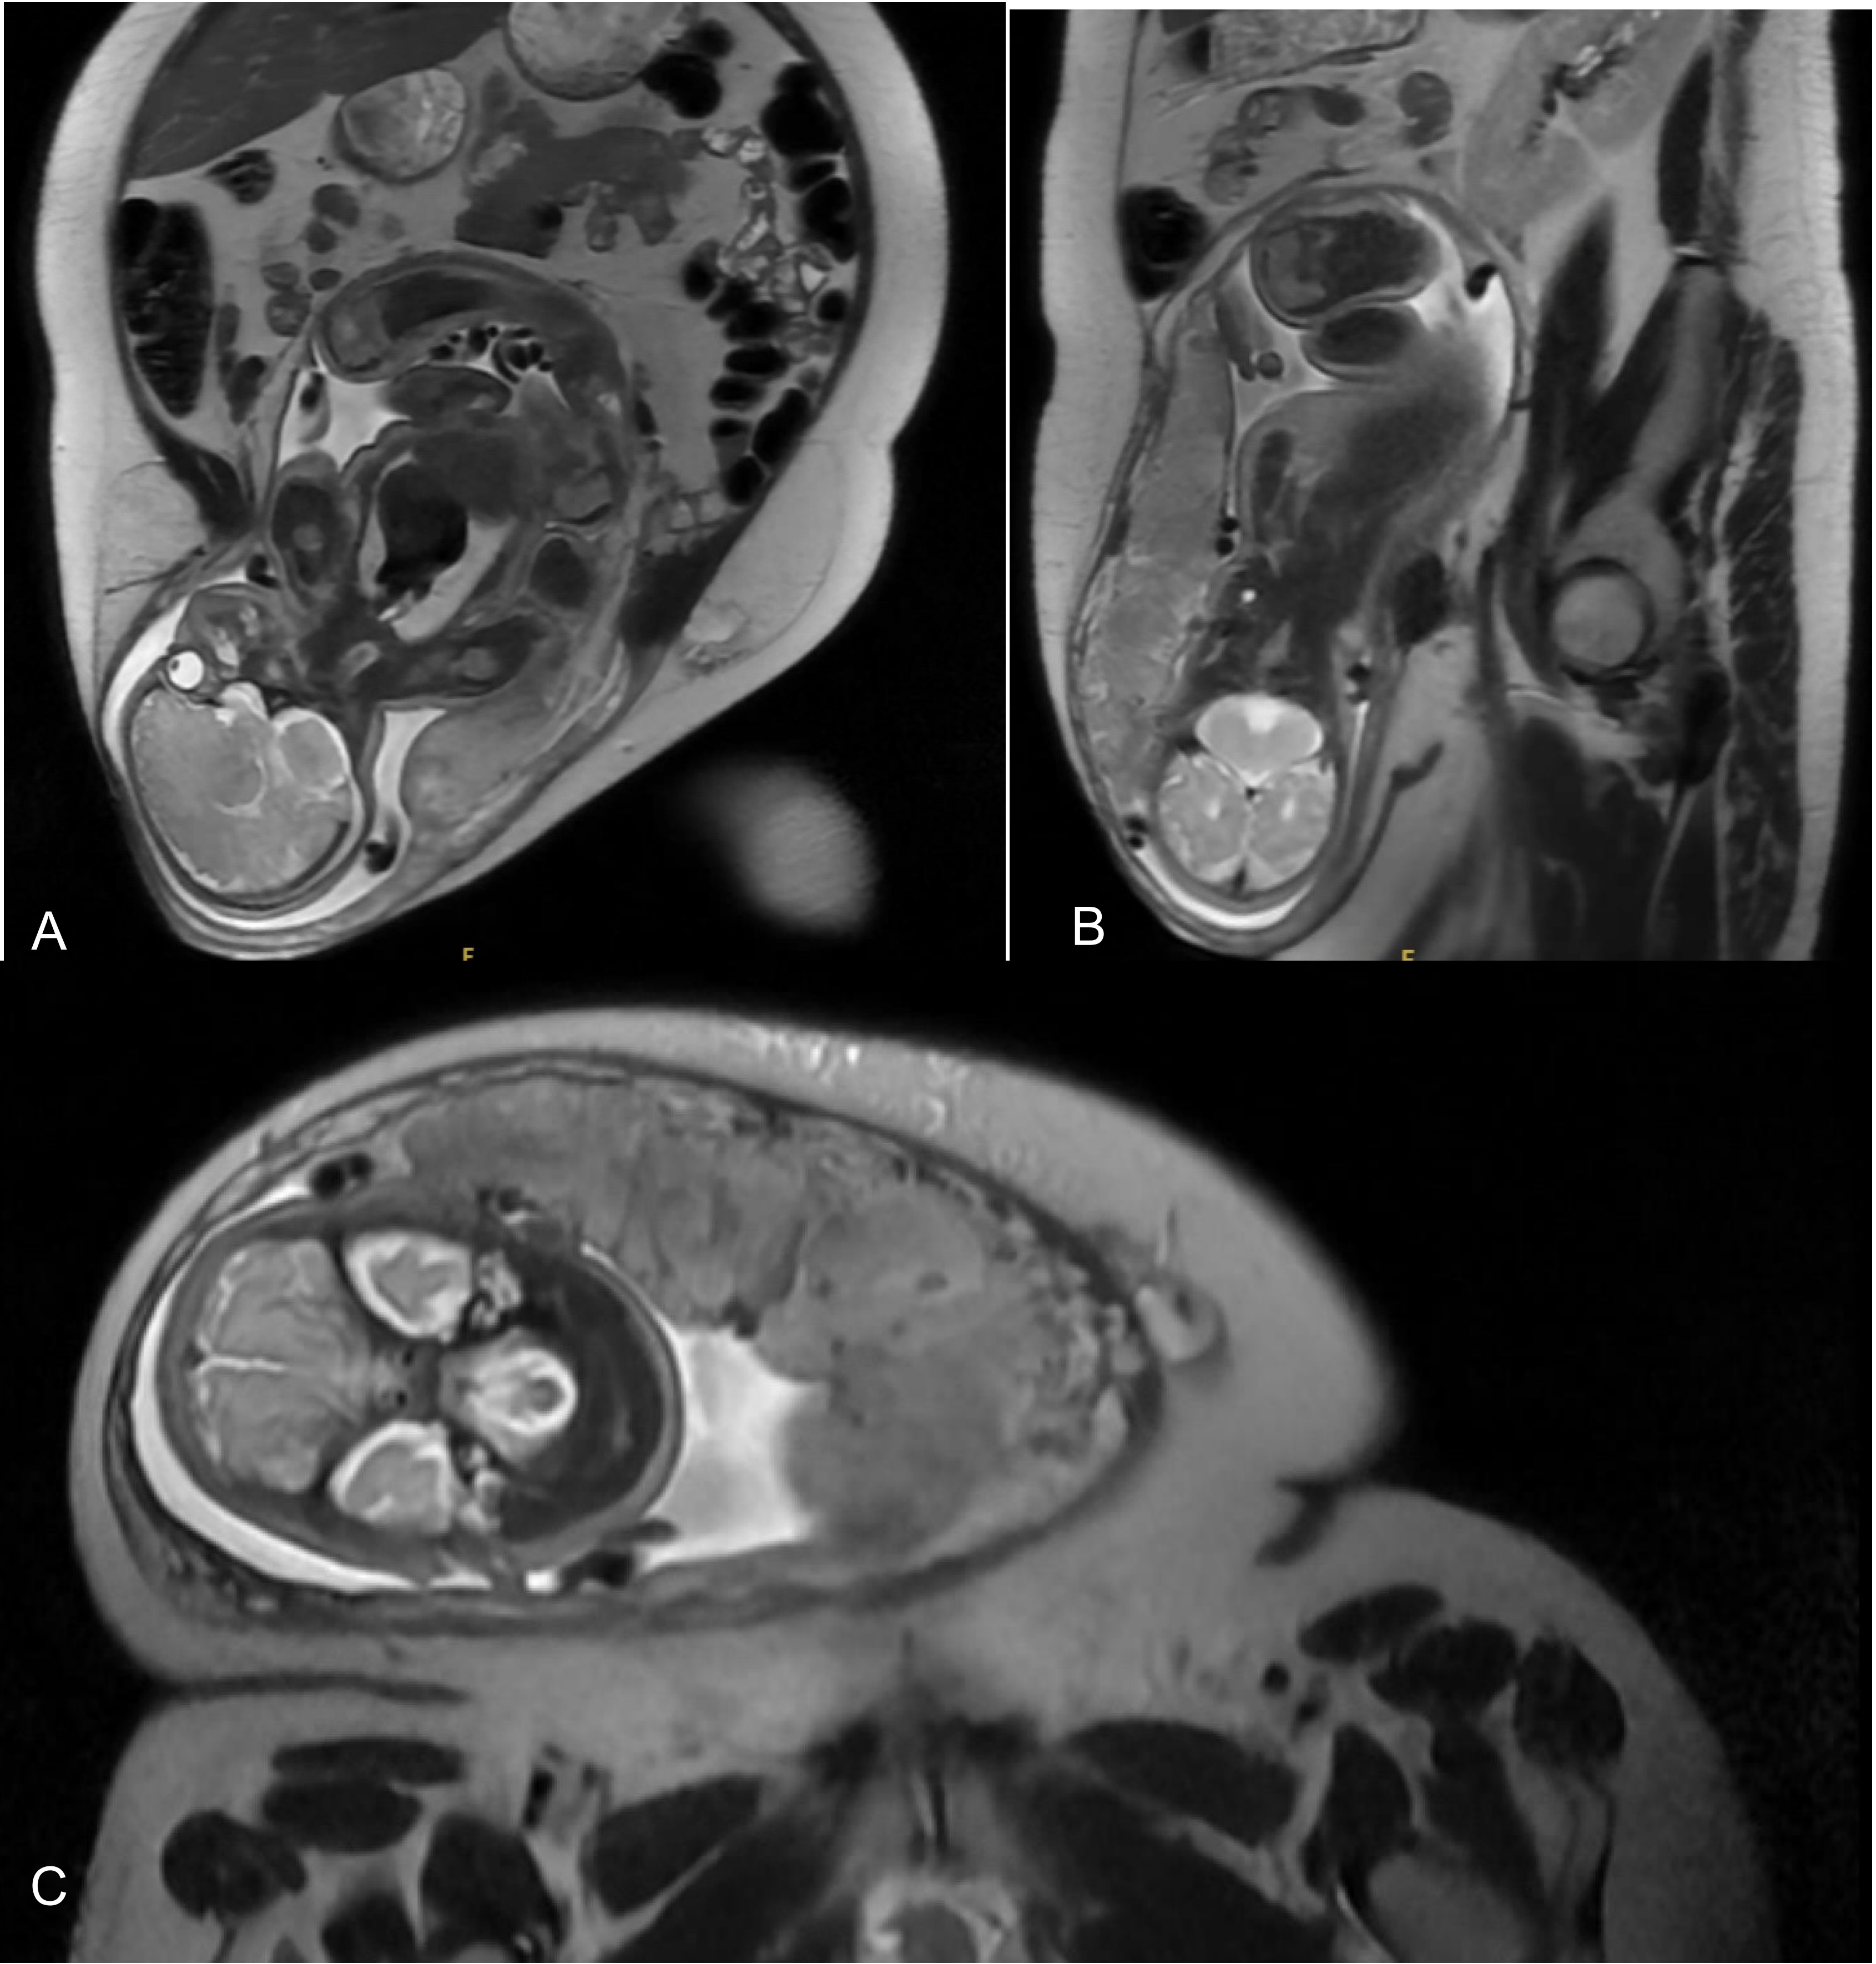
MRI in Coronal (A), Sagittal (B) and Axial (C) planes revealing the gravid uterus, Fetal head and placenta herniating through a large incisional hernia.
